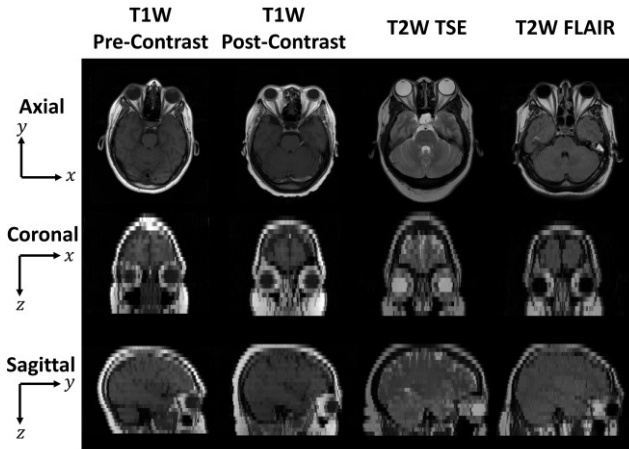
Representative in-plane (axial, first row) and through-plane (coronal, second row and sagittal, third row) slices for four MRI tissue contrasts from four different subjects. The coronal and sagittal through-plane slices are lower resolution than the axial in-plane slices and are visualized with nearest neighbor interpolation. The relatively lower resolution limits our ability to distinguish organs and generalize anatomical characteristics across populations.
